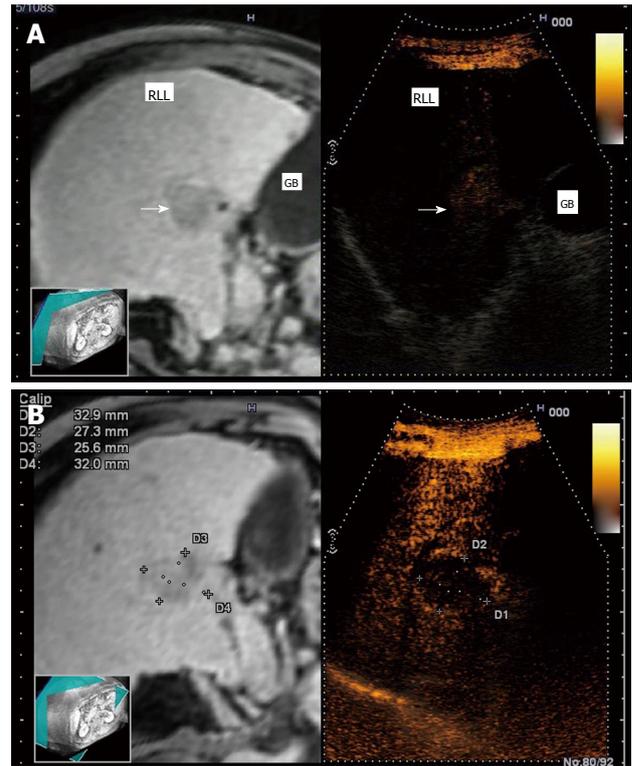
Single hepatocellular carcinoma (3 cm) nodule in a cirrhotic patient. In real-time virtual ultrasonography, after contrast agent injection, a progressive and intense enhancement is observed in the arterial phase (A), followed by wash-out in the tardive phase (B), on contrast-enhanced ultrasound, versus corresponding contrast-enhanced magnetic resonance images.
